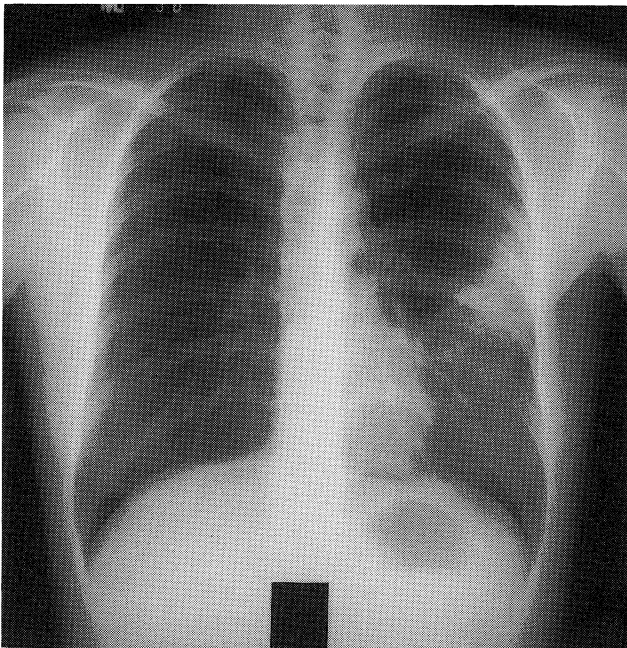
Chest radiograph of case 2 shows an infiltrative shadow in the left middle lung field.
